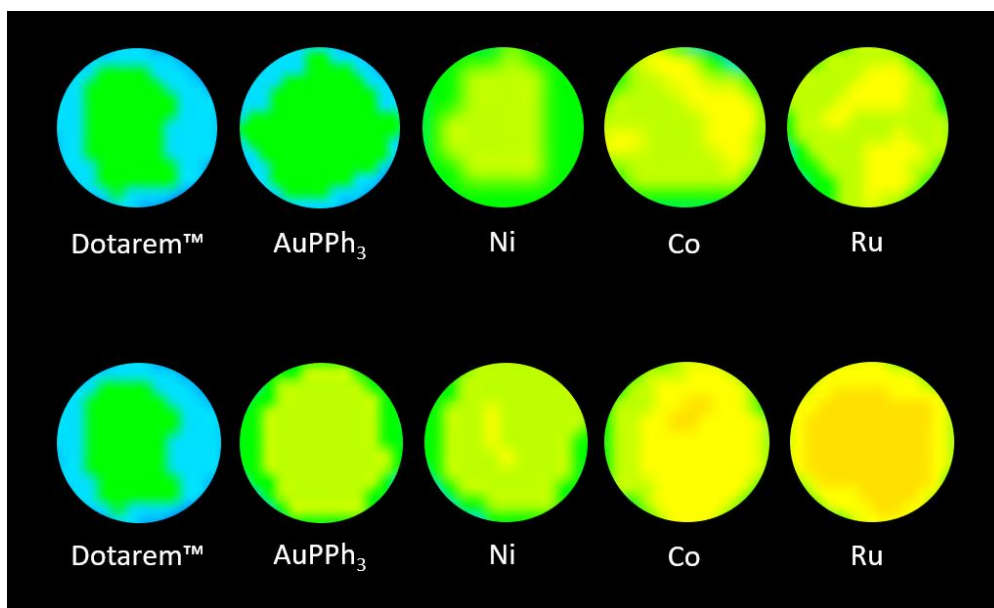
MR images (shown in '16 colors', ImageJ) of the metallostar complexes and Dotarem® (1.5 T, 25 °C, [Gd<sup>3+</sup>] = 0.2 mM).
